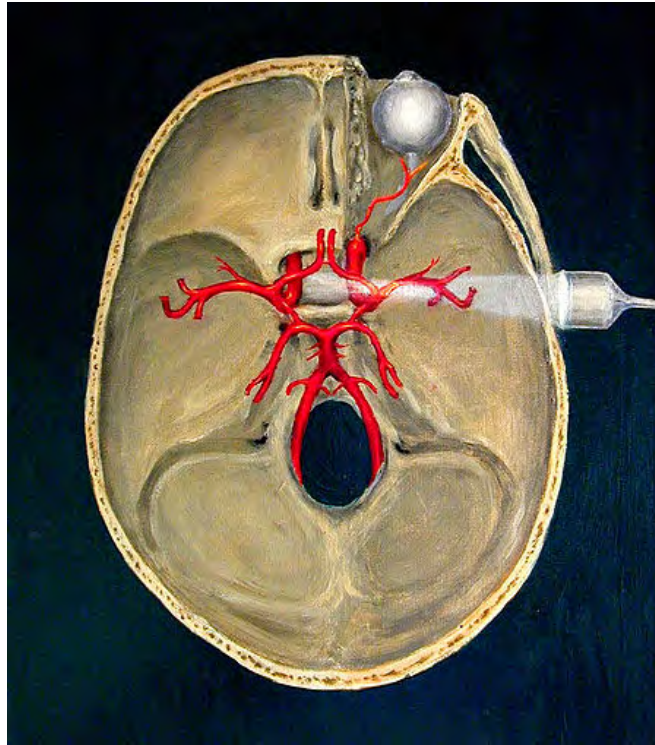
The transcranial doppler technique.
